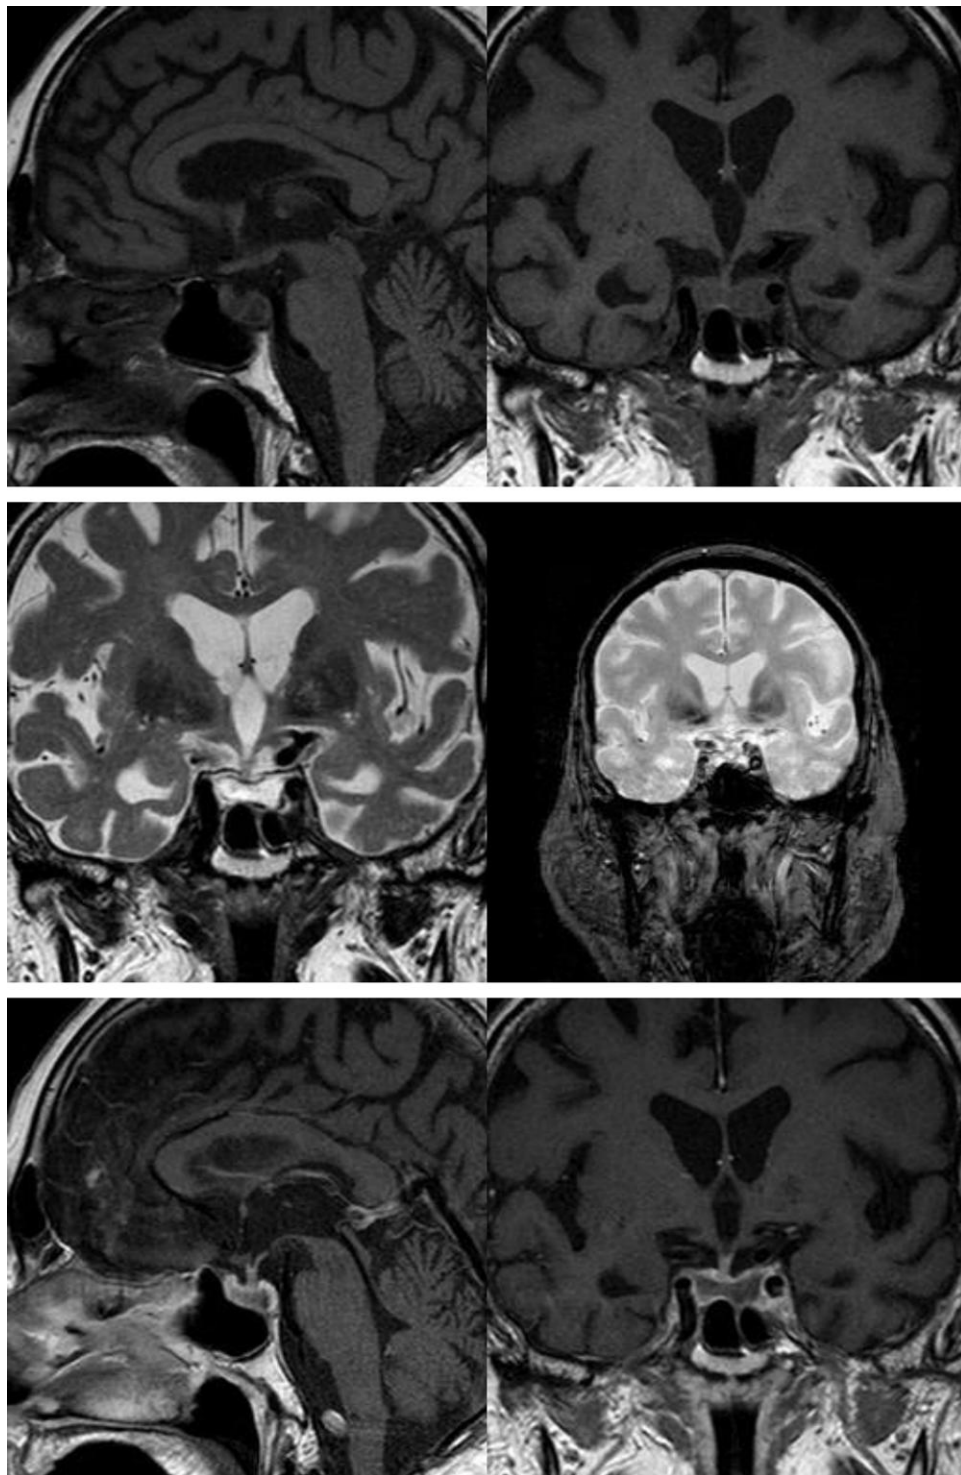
The last magnetic resonance imaging examination reported a morphological pattern that was partially normalized if compared to the first examination. In particular, a global reduction of the glandular size, a normal infundibulum and pituitary stalk enhancement, and a normal morphology of the cavernous sinuses were apparent while the persistence of absent spontaneous signal hyperintensity in T1 of the neurohypophysis together with a prevalent intraglandular signal cystic fluid with areas of low signal in T2* due to hemosiderin in previous intraglandular bleeding (pituitary apoplexy) were still present.
